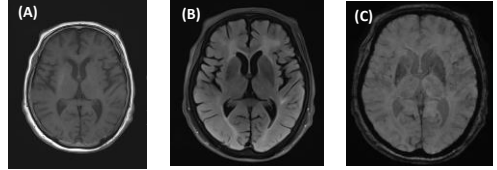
T1 weighted MRI(A) showed high signal in right basal ganglia, which was not detected in left side. T2 axial(B) and FLAIR(C) showed no significant abnormality in right basal ganglia.
